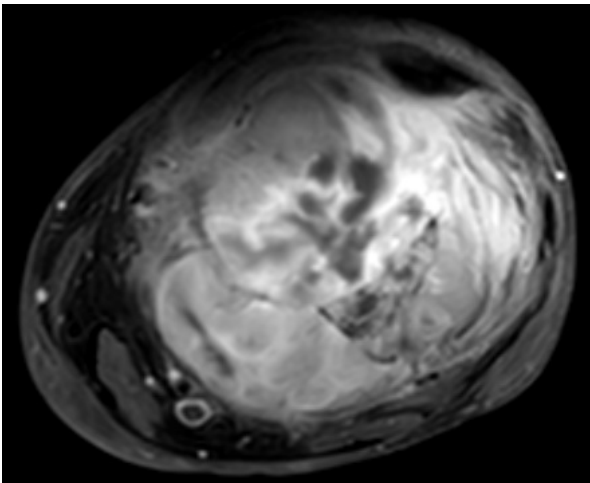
MRI-Post contrast T1W axial
